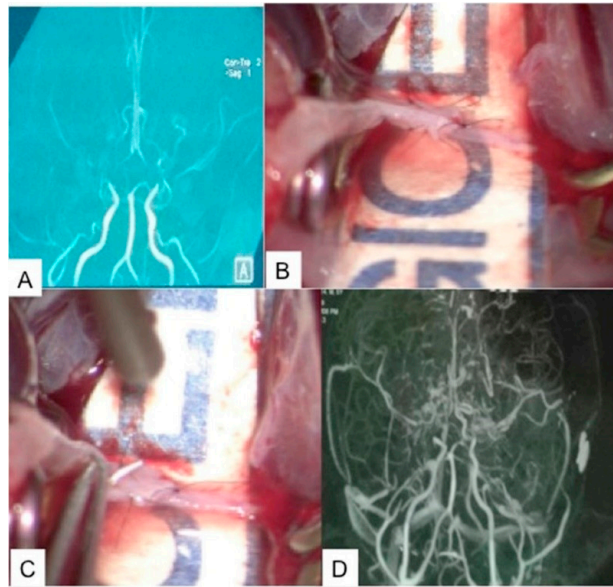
(A) MRA of the brain showing bilateral MMD in a 4-year-old child; (B,C) preoperative pictures of a direct STA-MCA bypass; (D) postoperative CTA on the first POD of the brain showing increased vascularity of the brain. Source: Figure by authors.
